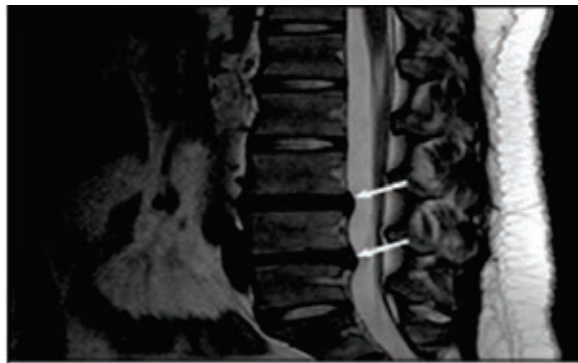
Magnetic resonance images of lumbar disc degeneration (LDD). The sagittal T2-weighted magnetic resonance image at L3-L4 and L4-L5 levels shows a degenerative signal loss with mild height reduction
